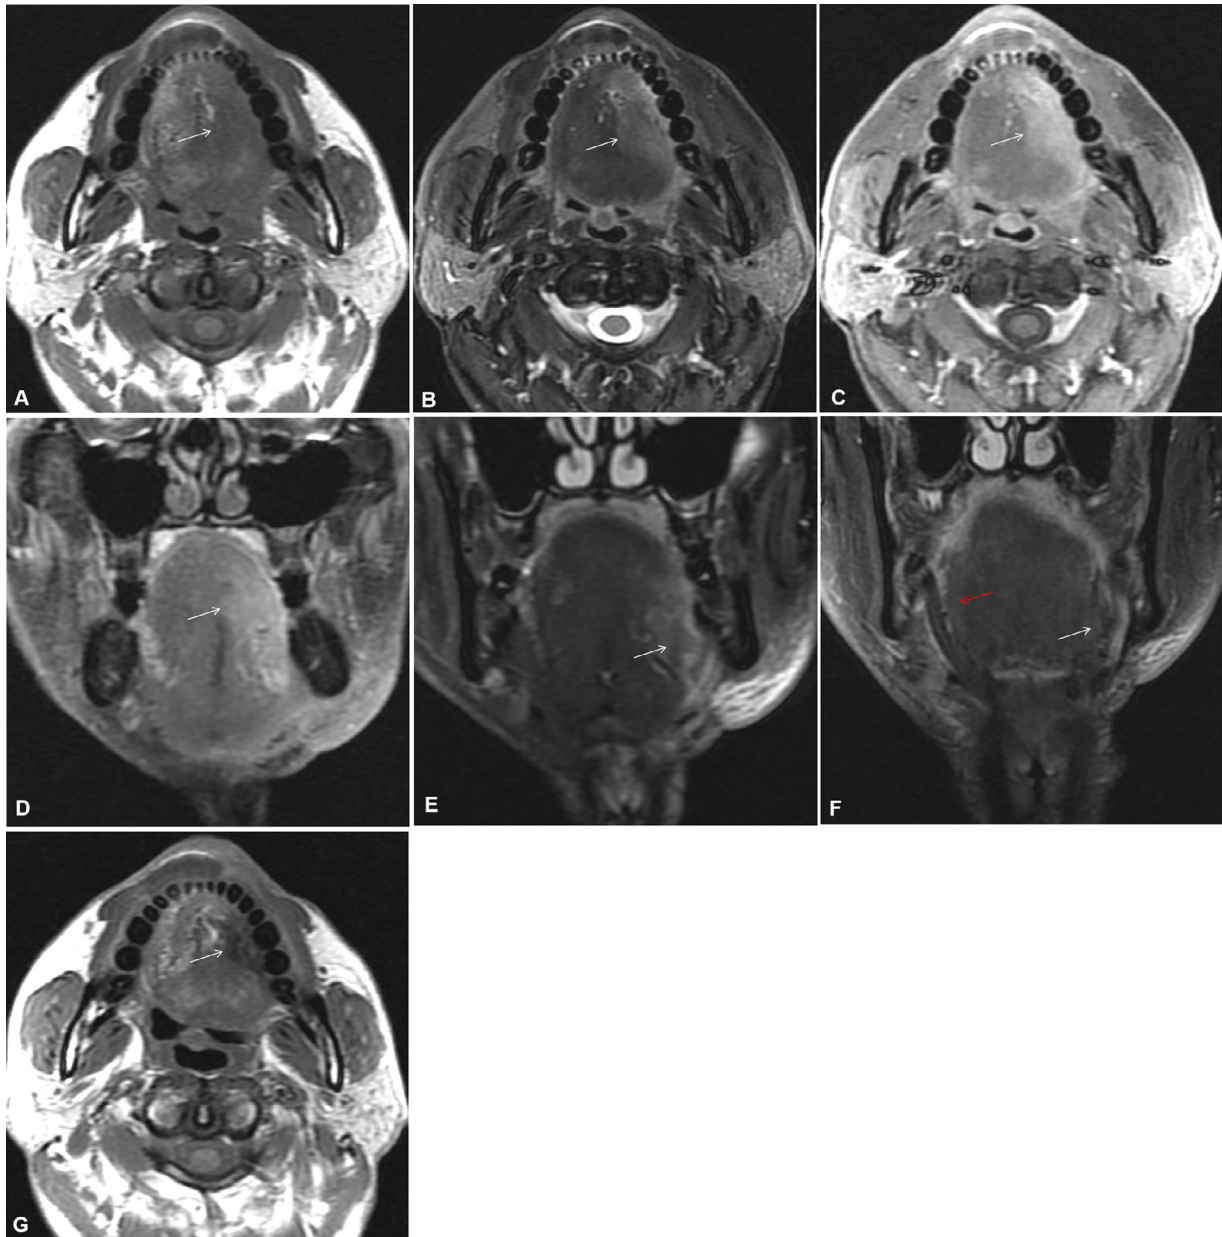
A 44-year-old man with cancer in the left body of the tongue following locoregional flap reconstruction. Parts A through E were obtained 1 month (in the period 0–4 months) after surgery. The flap shows isointensity with muscle on axial T1-weighted images (T1WIs), as indicated by the white arrow in (A) and hyperintensity on axial fast-spin (fs) T2-weighted images (T2WIs), as indicated by the white arrow in (B). Contrast-enhanced axial fast-spin T1-weighted images (T1WIs) (C) and coronal fs-T1WIs (D) demonstrate moderate enhancement with indistinct borders, as indicated by the white arrows. On coronal fs-T2WIs (E), the enlarged left hyoglossus muscle shows hyperintensity (white arrow). Part F was obtained 7 months (in the period 5–12 months) after surgery. The left mylohyoid muscle shows atrophy (white arrow) compared with the normal-appearing right mylohyoid muscle (red arrow) on coronal fs-T2WIs. Part G was obtained 28 months (in the period 13–48 months) after surgery. The flap demonstrates isointensity and atrophy (white arrow) on axial T1WIs.
